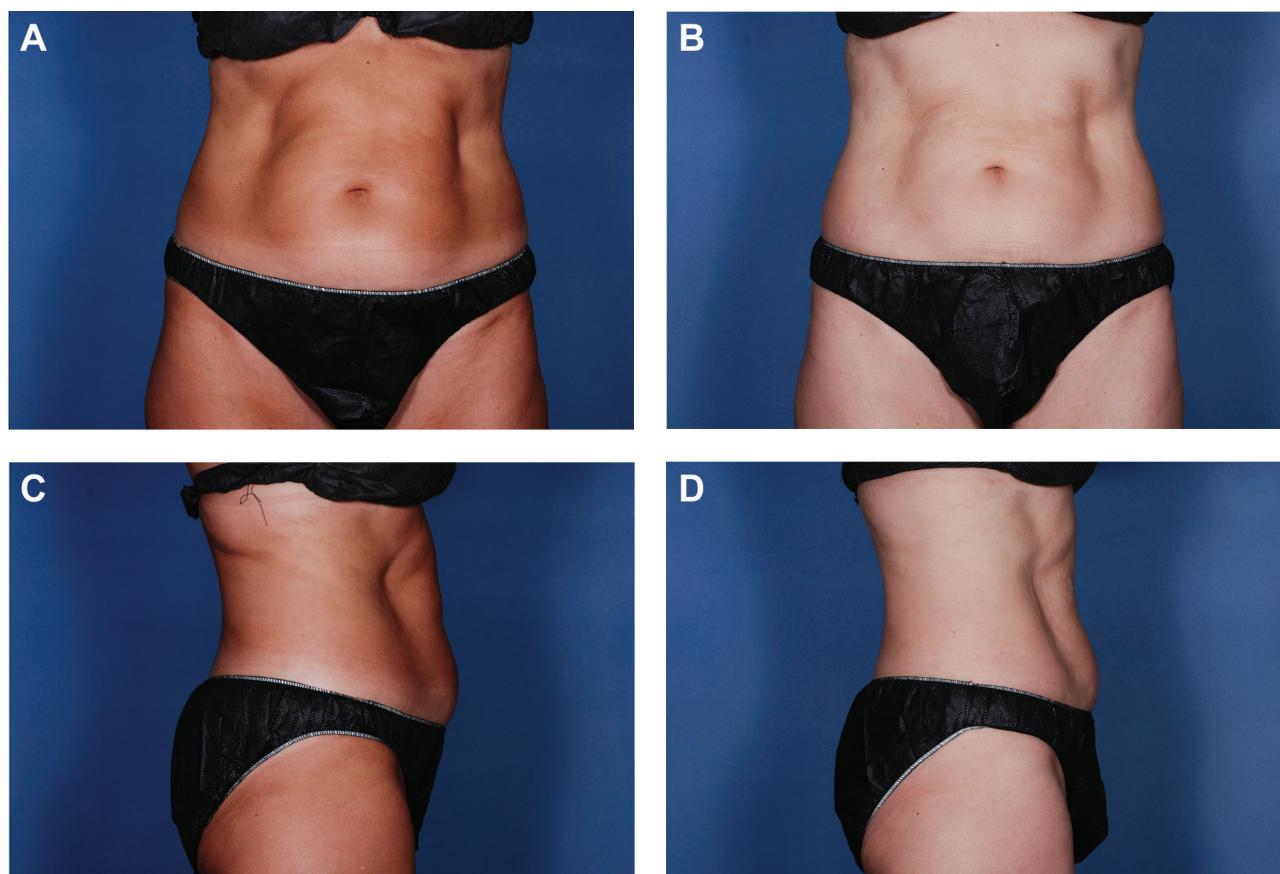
(A, C) This 42-year-old woman presented for treatment with high-intensity focused ultrasonography. (B, D) Twelve weeks after treatment with 3 passes of 59 J/cm². From baseline to 12 weeks posttreatment, her waist circumference decreased by 3.1 cm and her weight decreased by 0.3 kg.
